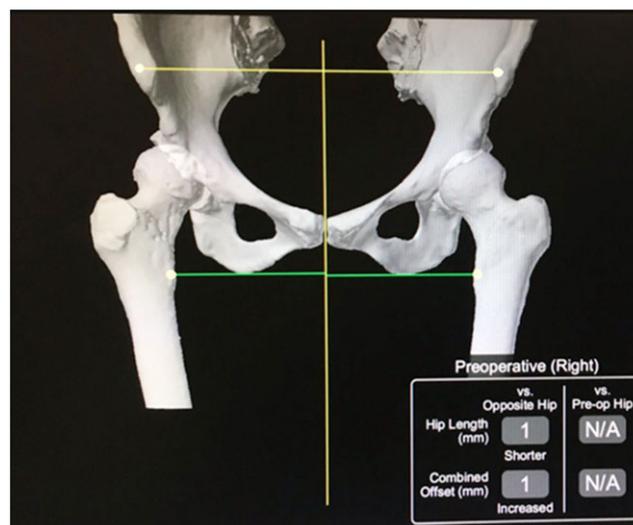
Three-dimensional model of the pelvis based on a preoperative CT scan. The leg length discrepancy (LLD) and offset are determined using the anterior superior iliac spine (ASIS) and the lesser trochanter (yellow dots) as landmarks. A horizontal line is drawn between ASIS landmarks (horizontal yellow line). A perpendicular vertical line is drawn from the ASIS line through the pubic symphysis (vertical yellow line). Lines are drawn perpendicular from this vertical line to each lesser trochanter landmark (green lines). LLD and offset are calculated by measuring the distance between the green lines
